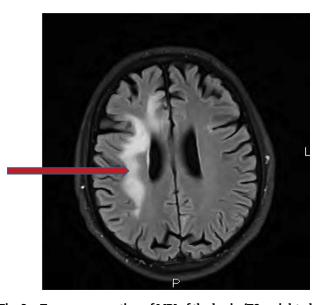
Transverse section of MRI of the brain (T2 weighted with gadolinium) demonstrates hyperintense signal in the right frontotemporal white matter.
